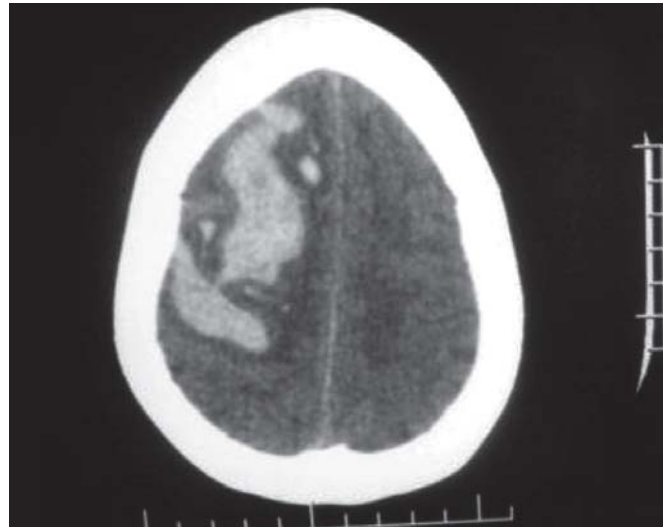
CT scan showing cerebral venous infarct
